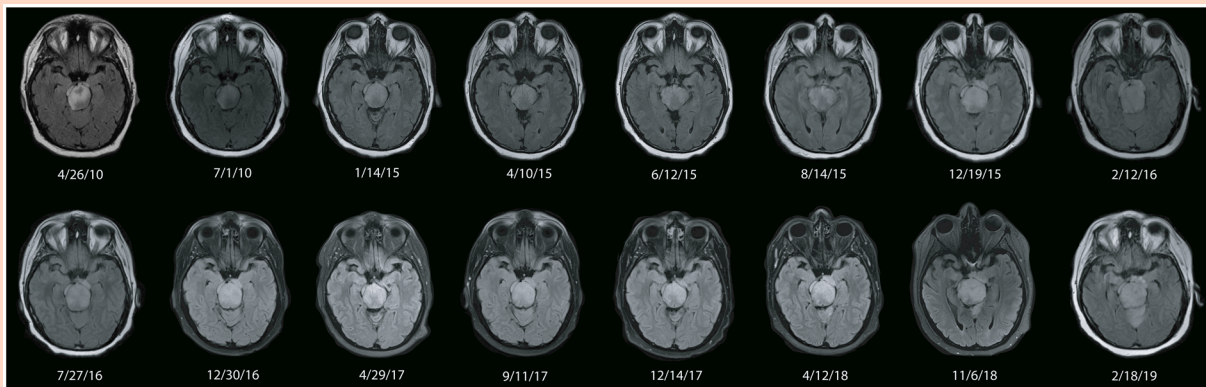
Serial axial T2 MRI of an IDH-mutant grade 3 brainstem astrocytoma (Case 3), showing slow radiographic progression over nearly a decade of follow-up.
